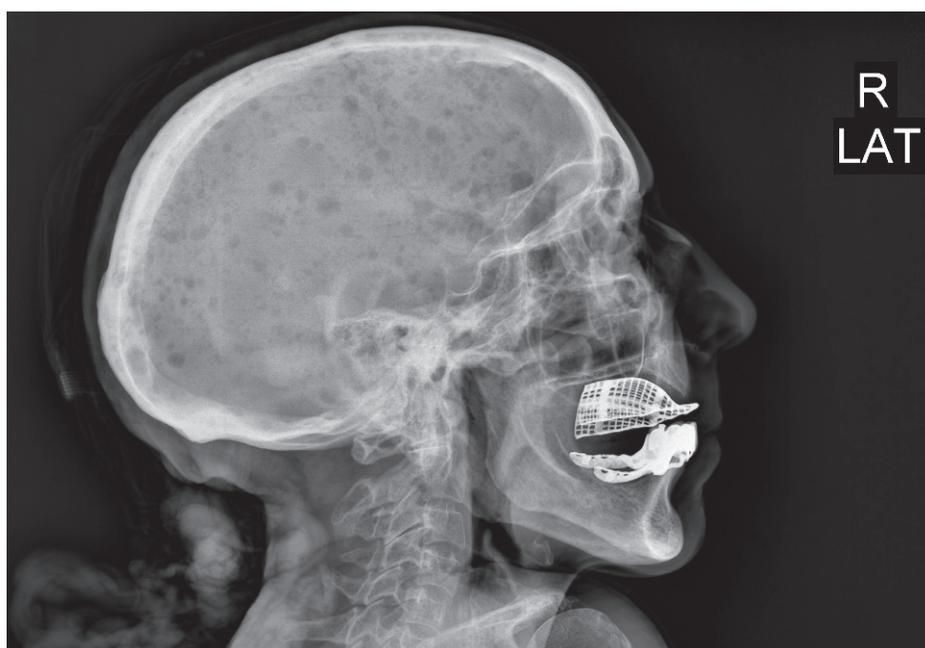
Lateral skull radiography of the patient demonstrating typical punched out lesion in favor of multiple myeloma.
